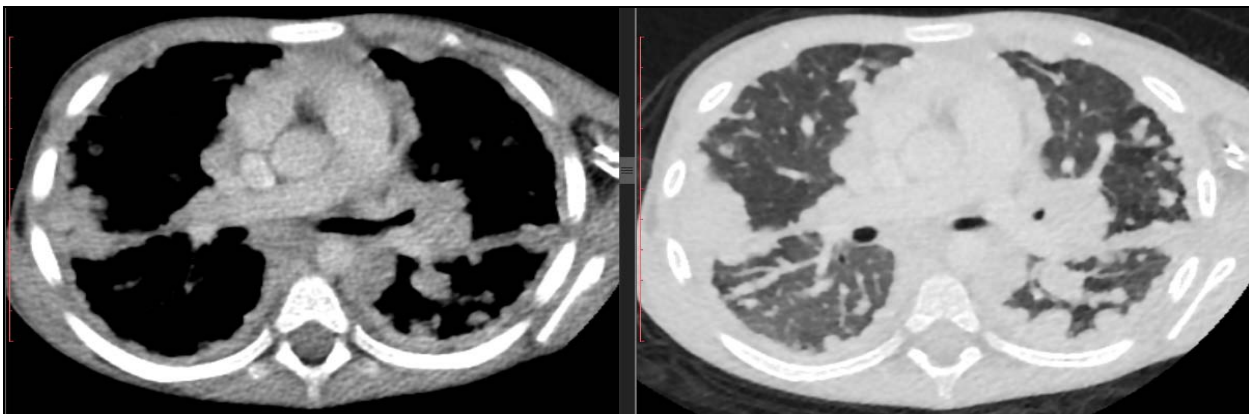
Chest CT scan: diffuse different size bilateral lung nodules and multiple fissural nodules. There is also bilateral nodular pleural thickening involving both the costal and mediastinal pleura, and fissures.
